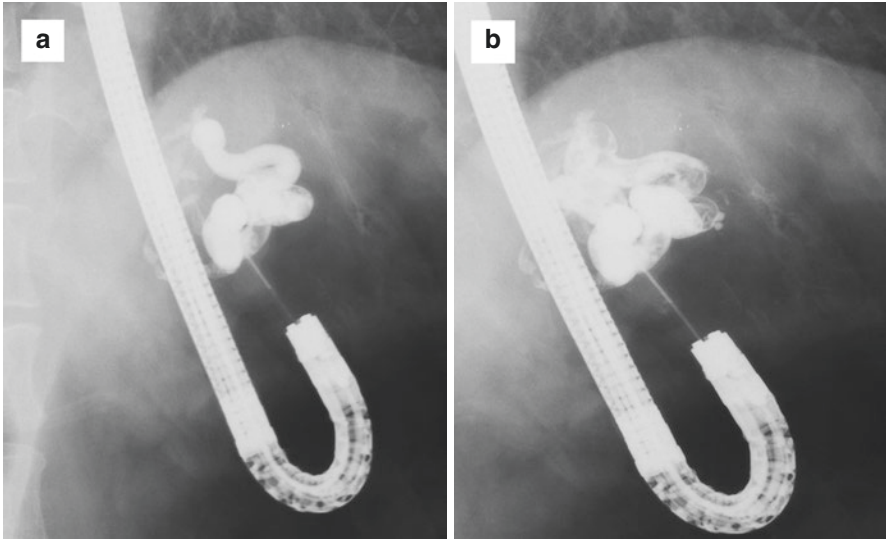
X-ray varicography images obtained in a representative patient during the endoscopic injection of a mixture of Histoacryl and Lipiodol. The GV, which consisted of a single varicose vessel, was completely obstructed via two injections of a mixture of Histoacryl and Lipiodol. (a) X-ray images obtained during the second injection. The injection was halted when the mixture of Histoacryl and Lipiodol filled the region extending from the puncture site to the juxta-variceal portion of the outflow vein. (b) X-ray images obtained during the first injection. The injection was halted when the mixture of Histoacryl and Lipiodol filled the region extending from the puncture site to the juxta-variceal portion of the inflow vein
